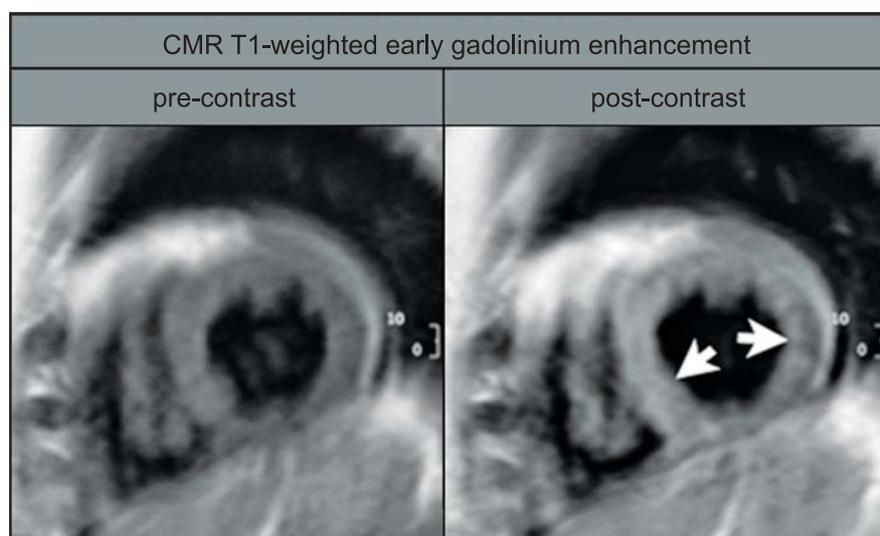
T1-weighted short-axis spin-echo images before (left) and after (right) gadolinium infusion with early gadolinium accumulation in the septum (white arrows) indicative of myocardial inflammation. Reprinted with permission from Friedrich et al.²⁸
